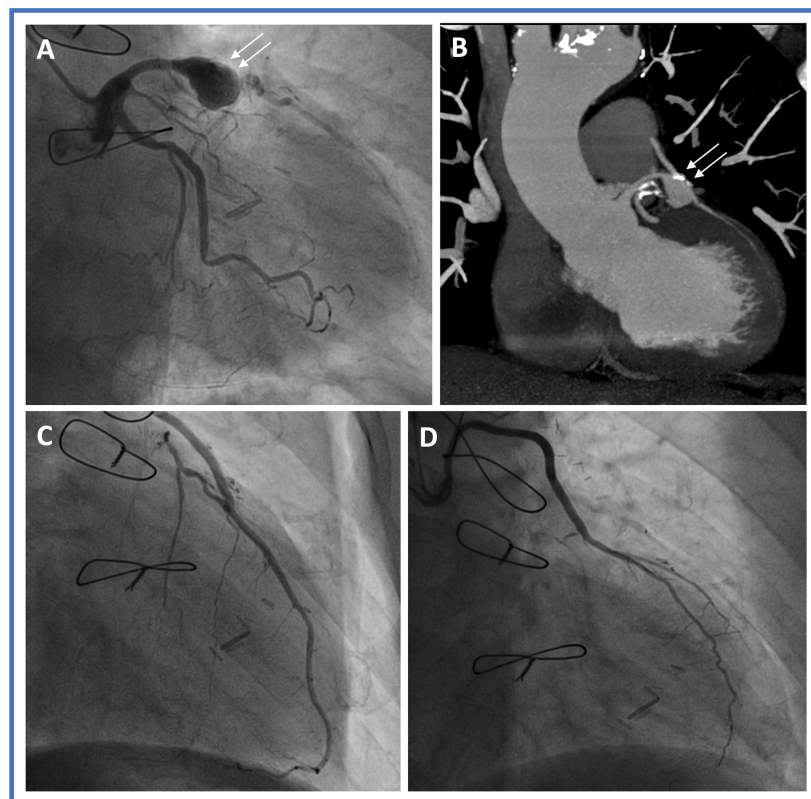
Angiographic (A) and CT-scan (B) appearance of a LAD saccular aneurysm (double arrows) in a patient with prior CABG. (C and D) show patency of LIMA to LAD and SVG to OM grafts, respectively. CT: Computed tomography; LAD: left anterior descending artery; CABG: coronary artery bypass grafting; LIMA: left internal mammary artery; SVG: saphenous vein graft; OM: obtuse marginal.
